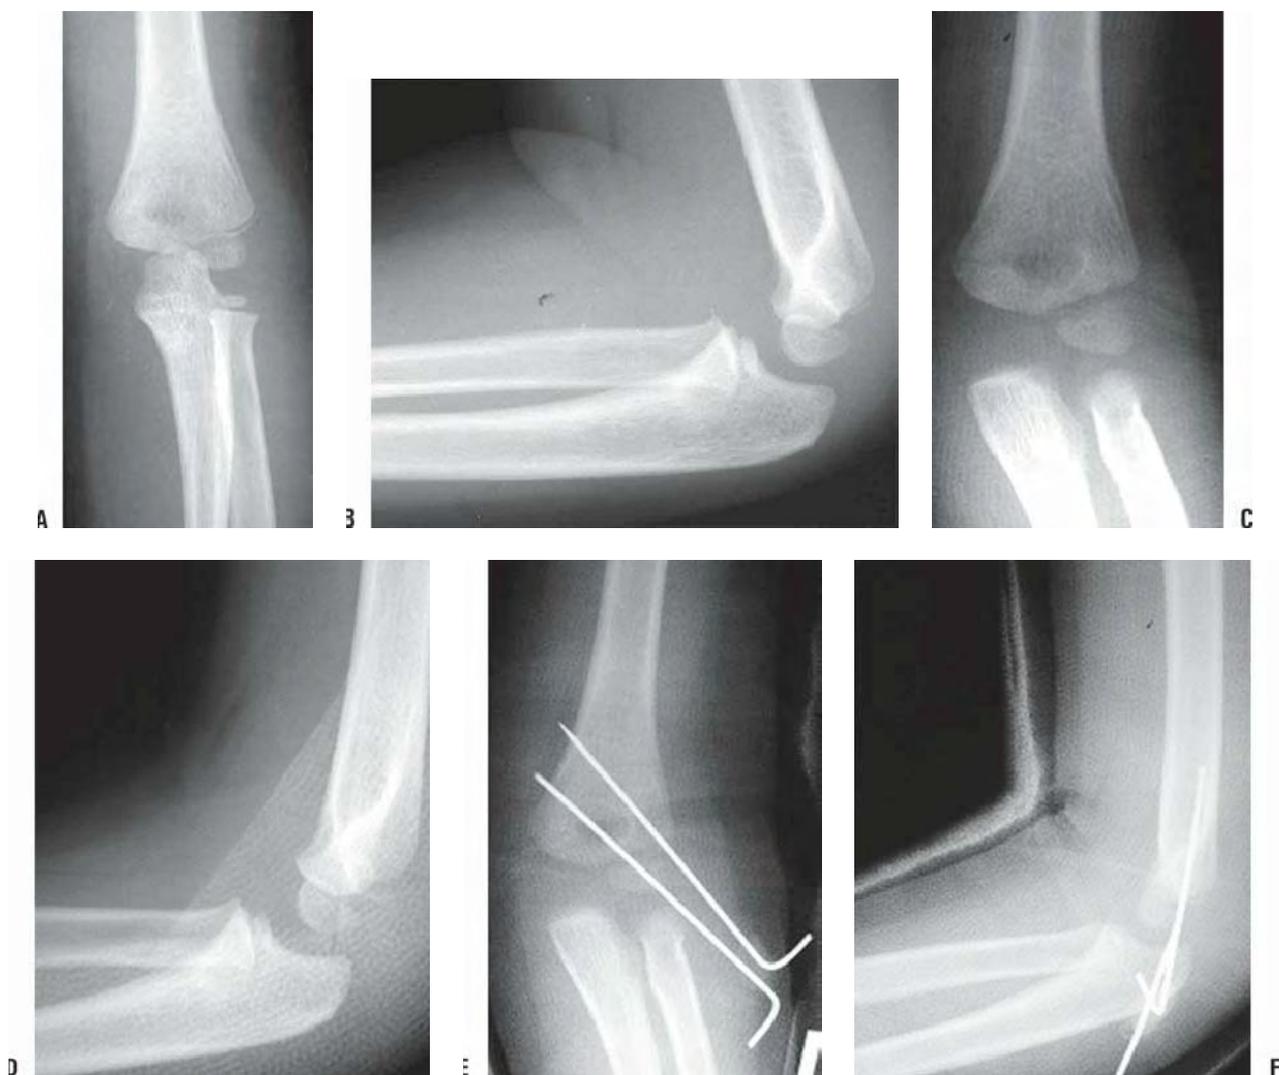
The drifting lateral condyle fracture. A, B: AP and lateral radiographs at presentation. This lateral condyle fracture has only approximately 2 mm of displacement on the AP view. No displacement is noted on the lateral view. The child was placed in a long-arm cast and a follow-up 1 week later was recommended. C, D: AP and lateral radiographs taken 1 week after injury show further displacement of the lateral condyle fracture with 5 mm of separation of the lateral condyle from the distal humerus. Open reduction and pinning was performed. E, F: Radiographs taken in the cast 4 weeks after open reduction and pinning show anatomic alignment and early healing.
